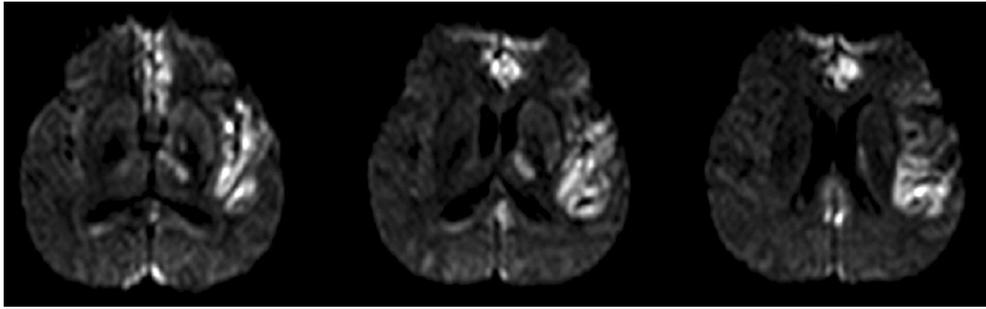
DWI showing multiple areas of cerebral infarction in patient with acute pyogenic meningitis.
